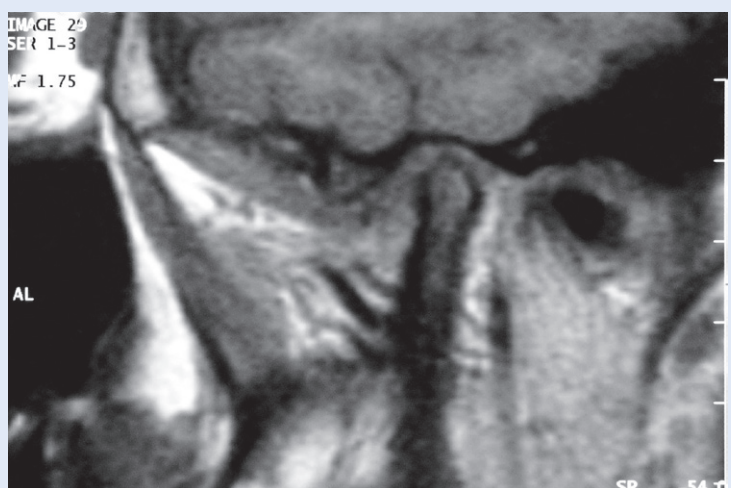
MRI of the right TMJ with the splint applied in closed mouth position. Note: condyle was situated in a therapeutic position posteriorly within the glenoid fossa
